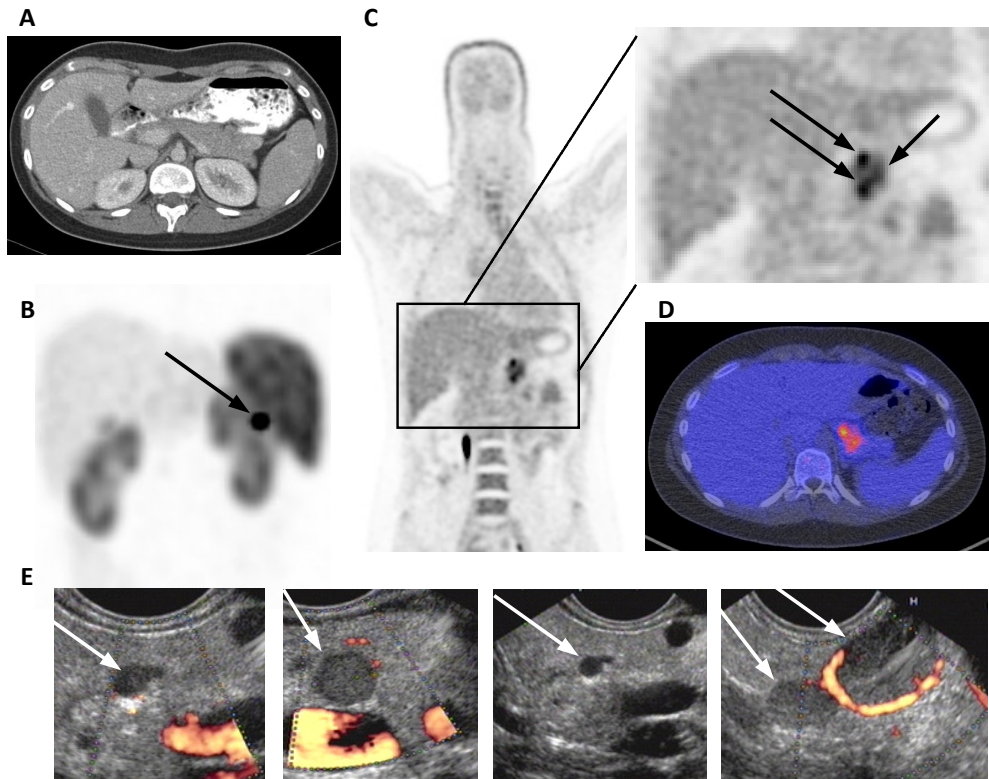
A Axial image of CT scan, B maximum intensity projection image of SRS and C coronal image of ^{11}C -5-HTP PET and D an axial fusion image of ^{11}C -5-HTP PET with low-dose CT and E images of pancreatic lesions visualized with EUS. With CT no lesion was found and SRS showed 1 lesion located in the pancreatic tail. With ^{11}C -5-HTP PET 3 lesions were visualized in the pancreatic body/tail region. However, EUS visualized 5 hypochoic lesions: 4 in pancreatic body/tail region and 1 in the pancreatic head, with size ranging from 3.5-14 mm. The lesion of 14 mm showed a clear hypervascular wall with power Doppler.
